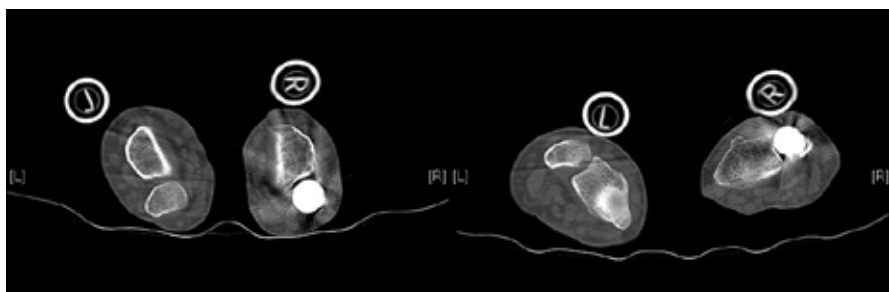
CT images showing position of Herbert prosthesis in neutral and pronated forearm rotation.
